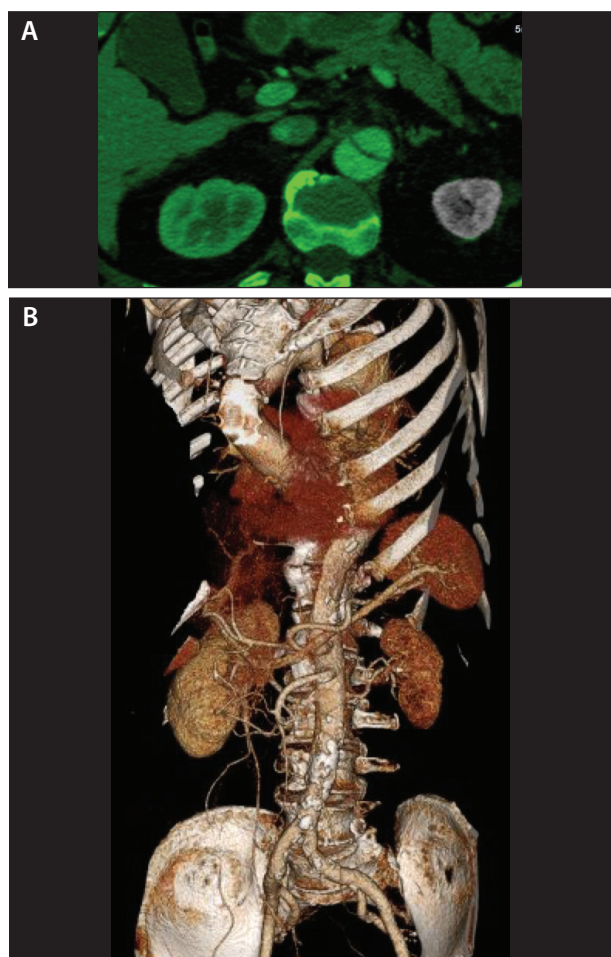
An axial (A) and three-dimensional reconstruction (B) CT scan of a patient with a shrunken right kidney 3 years after “uncomplicated” TBAD.
